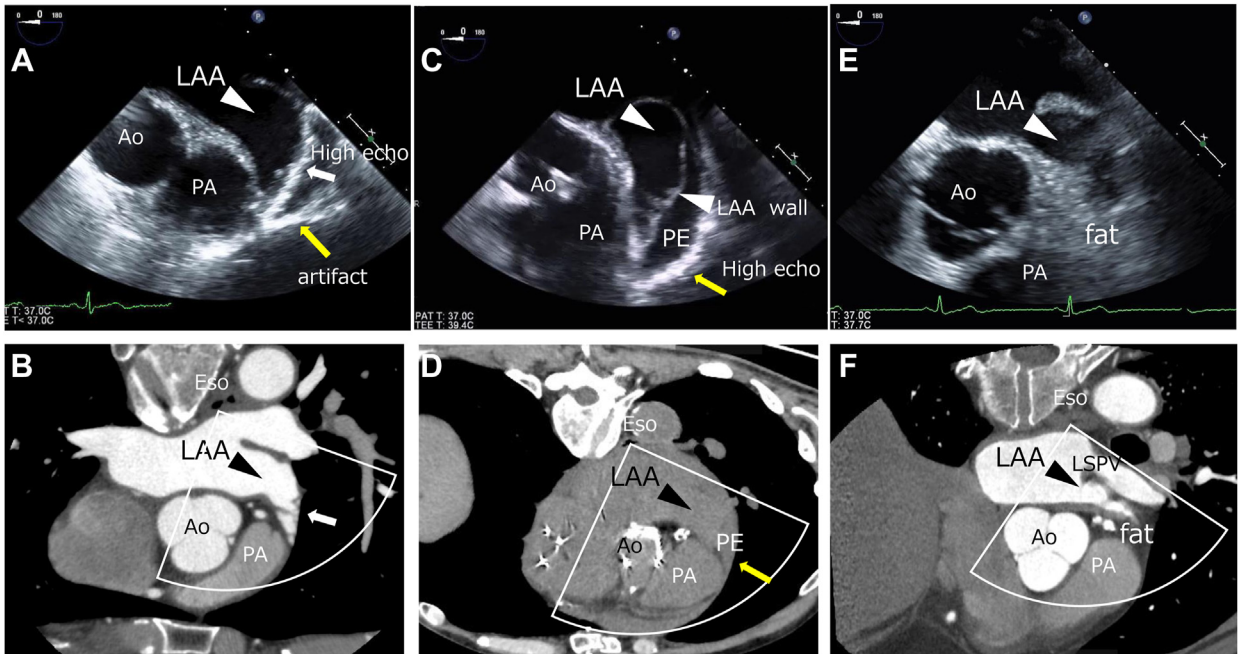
Two-dimensional upper esophageal transesophageal echocardiographic images of the LAA at 0° (upper panels) and comparison CCT images (lower panels). Case 1 (A, B): High-echoic partition with reflection artifact. The high-echoic partition (white arrow in A) corresponds with the pericardium attached the lung (white arrow in B). The artifact (yellow arrow in A) corresponds with no significant structure other than the lung. Case 2 (C, D): High-echoic partition with pericardial effusion. The high-echoic partition (yellow arrow in C) corresponds with the pericardium attached the lung (yellow arrow in D). Case 3 (E, F): No high-echoic partition with fat. The LAA is surrounded by fat. Ao, aorta; Eso, esophagus; LAA, left atrial appendage; PA, pulmonary artery; PE, pericardial effusion.
